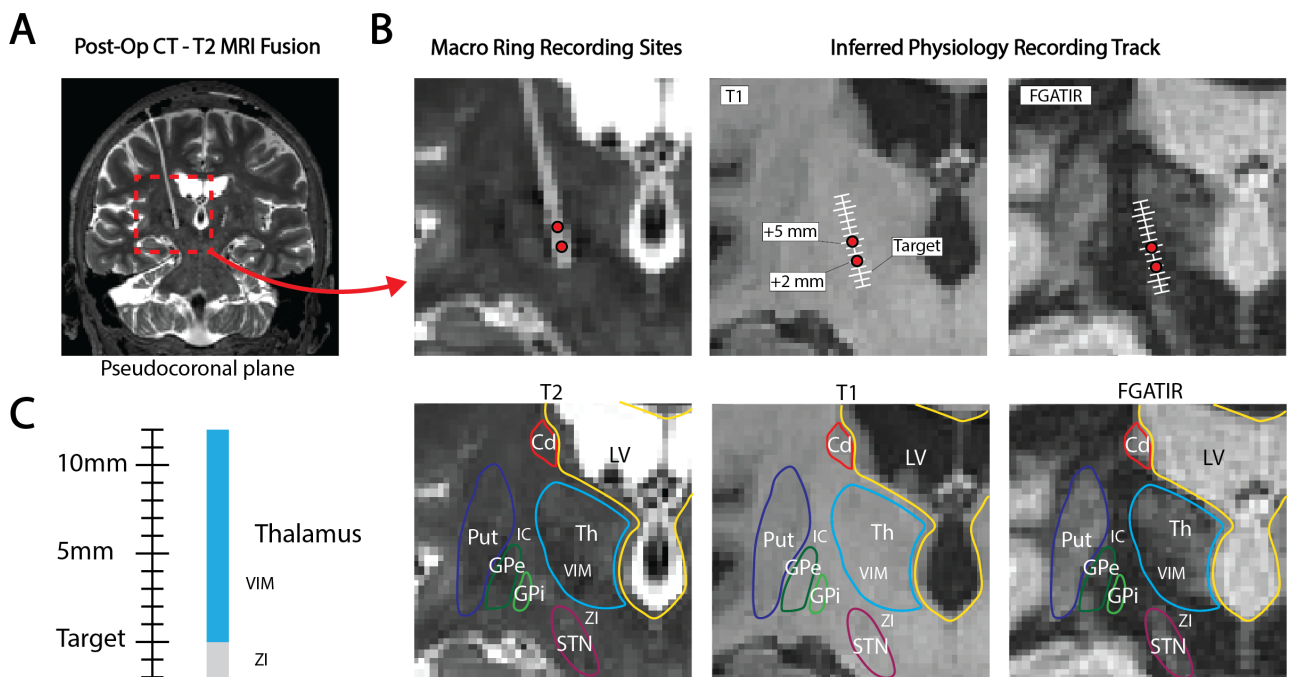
DBS lead localization and anatomical segmentation (A) Post-op CT - T2 MRI fusion showing final lead position on brain anatomy. Pseudocoronal image is resliced in-plane with DBS lead while maintaining midline symmetry. (B) Identification of thalamic microelectrode macro ring recording sites through lead localization. (C) Inferred anatomical segmentation along physiologic recording track.
